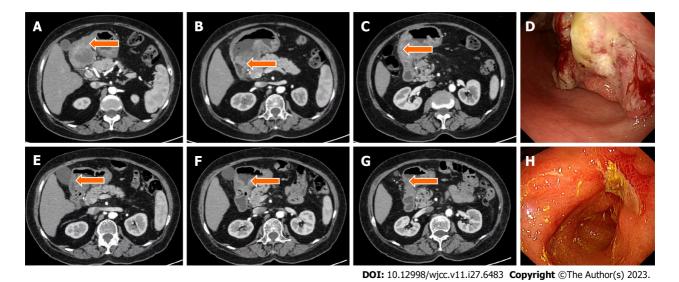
Computed tomography and gastroscopy images before and after treatment. A-C: Computed tomography (CT) images of primary lesions before immunotherapy combined with chemotherapy; E-G: CT image of the primary lesion significantly reduced after immunotherapy combined with chemotherapy; D: Gastroscopy image before immunotherapy combined with chemotherapy, H: After immunotherapy combined with chemotherapy, the antral mass was significantly reduced by gastroscopy.
